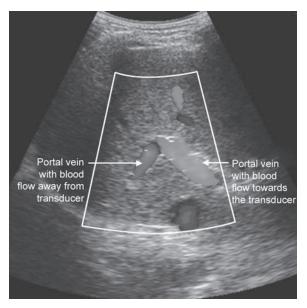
Liver image, a Doppler interrogation box placed over the portal vein
